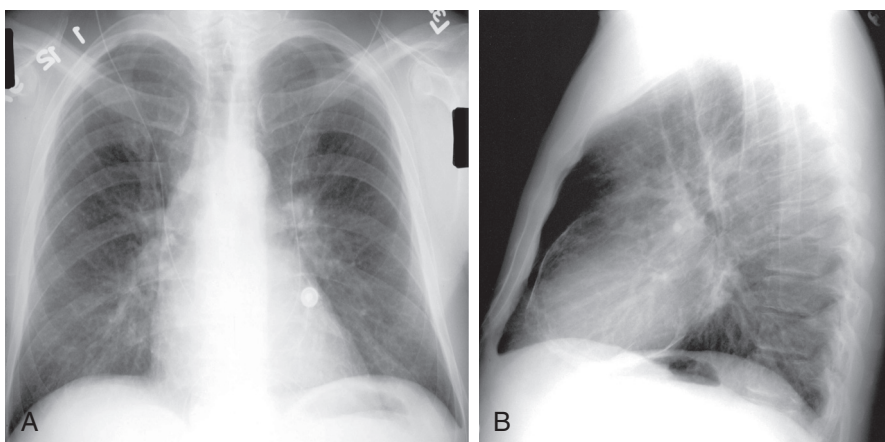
Chest radiographs of a 45-year-old man with calcific pericarditis. A, The PA view is essentially normal. B, A lateral view demonstrates thin, irregular calcification of the pericardium around the left ventricular contour.
